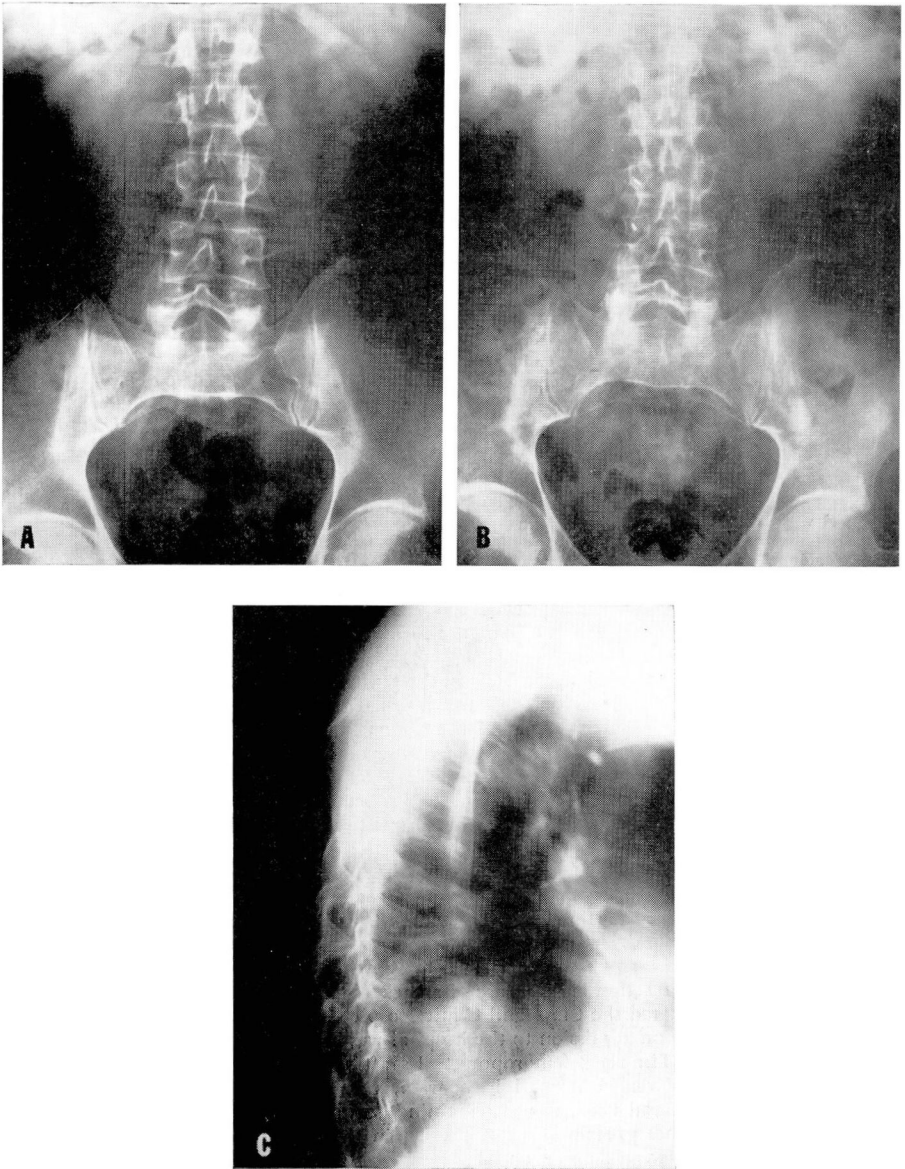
Plain roentgenograms of the spine showing: A, a normal lumbar spine on April 30, 1962, just before heparin therapy was instituted; B and C, severe demineralization of the spine with compression fractures of the sixth and eighth thoracic vertebrae, on January 15, 1963, when the administration of heparin was discontinued.
